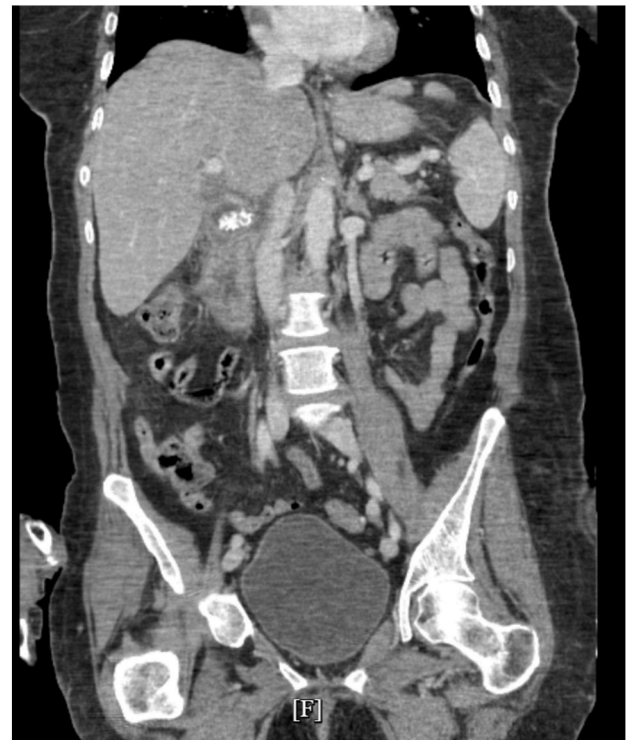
CT scan of the abdomen and pelvis revealing an unremarkable urinary bladder.
